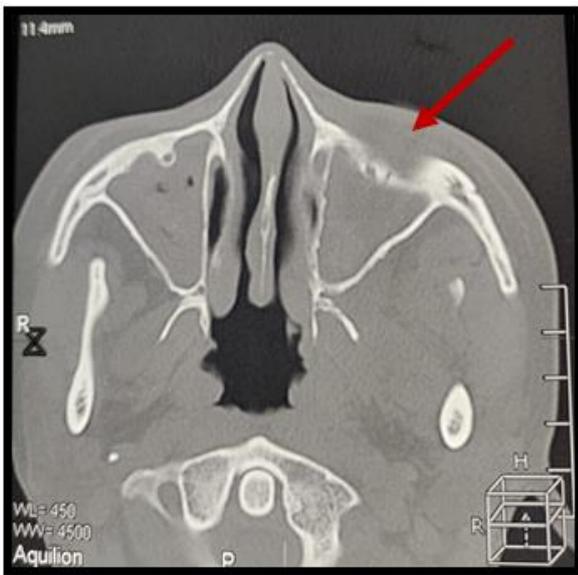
CT shows bony erosion of the left maxilla
